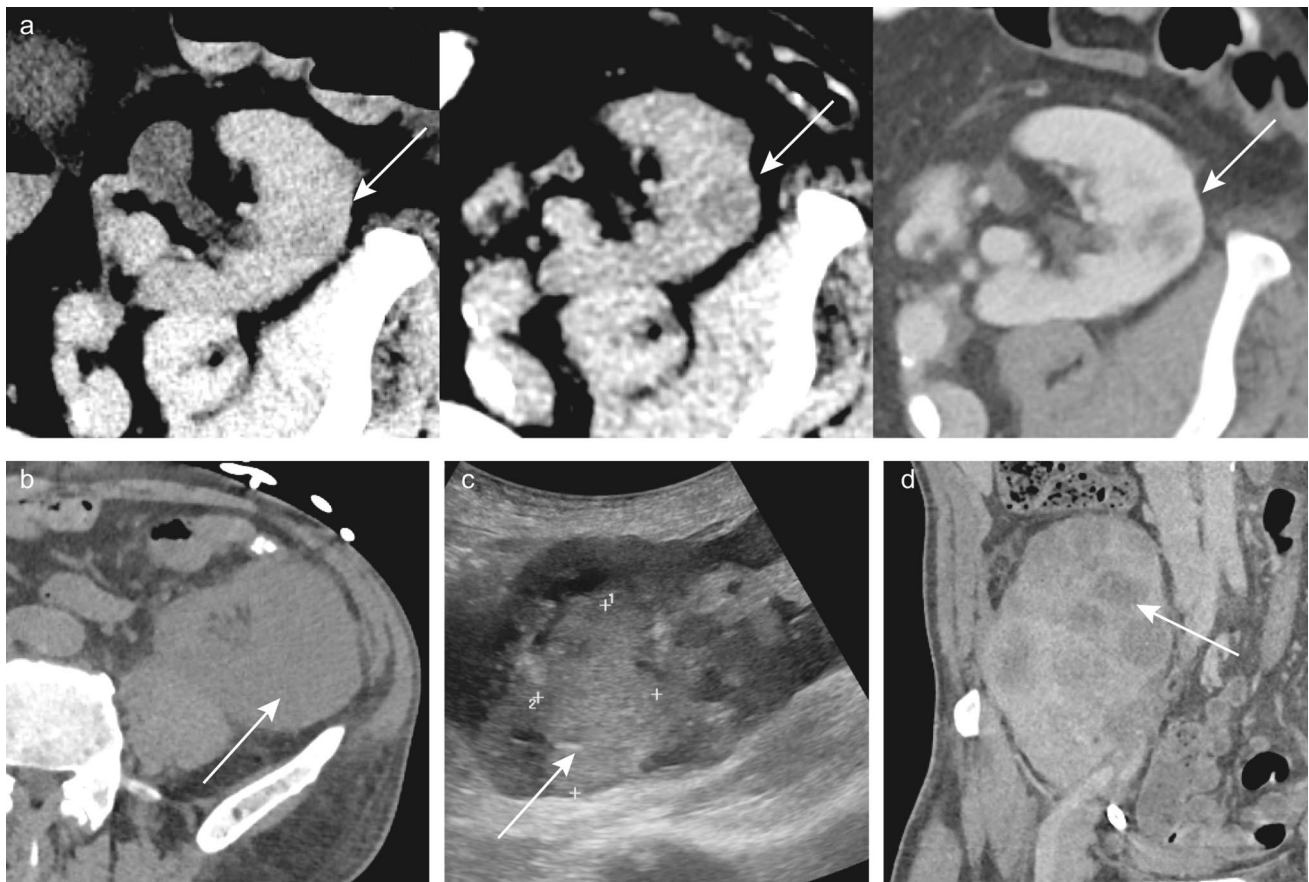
Post-transplant mass lesions. a Growth of a solid mass in the allograft unnoticed among cysts on noncontrast CTs for two years before showing enhancement on contrast-enhanced CT. Biopsy showed oncocytoma. b Mass-like expansion of the graft on non-contrast CT suspicious for neoplasm, confirmed on c follow up
